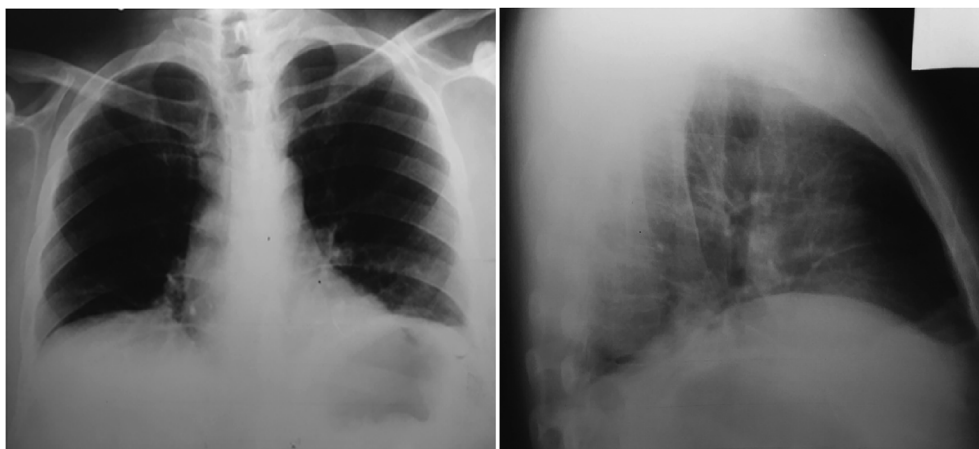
Chest radiograph showing elevation of both hemidiaphragms and reduced lung volumes.
